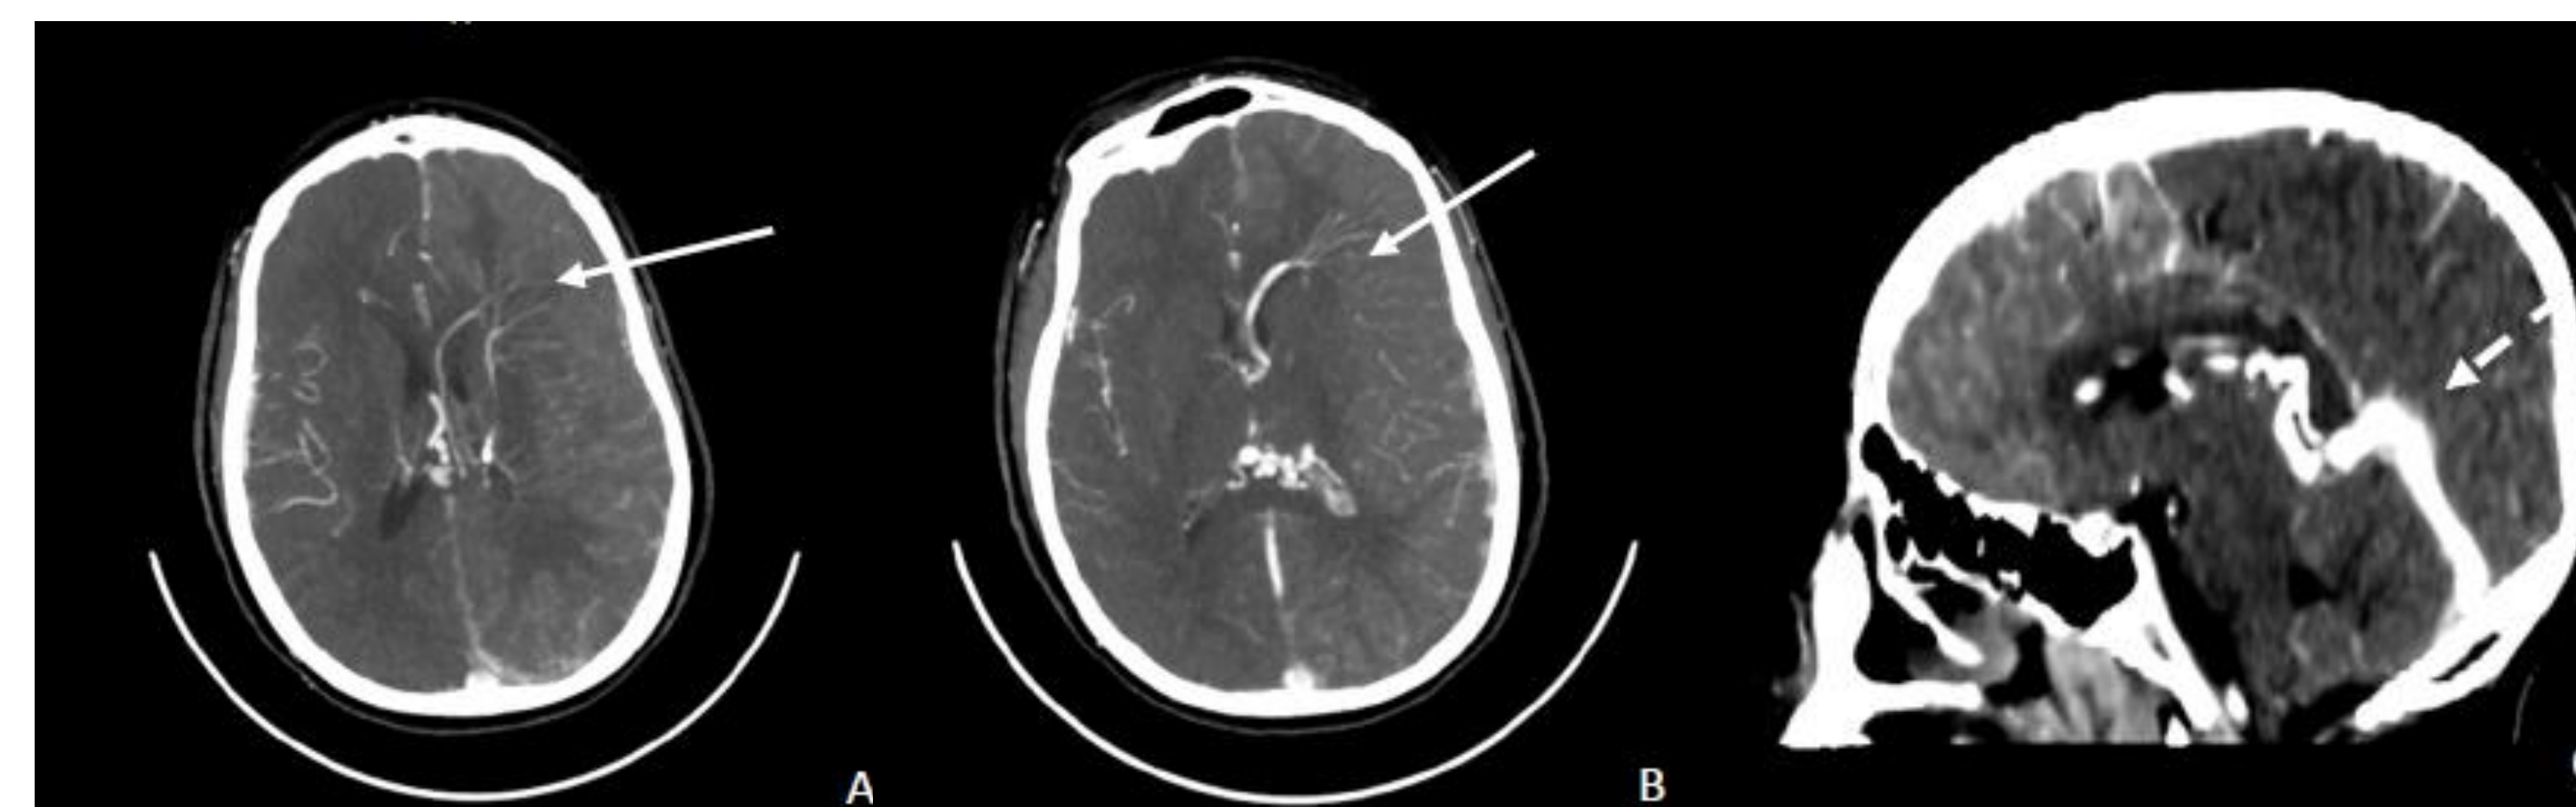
CT angiogram. Axial view (A,B) coronal (C). Left cerebral leptomeningeal angiomas and 2 enlarged veins within the left periventricular left frontal lobe and in the corona radiata (arrows) which drain into an enlarged Vein of Galen (dashed arrow).
